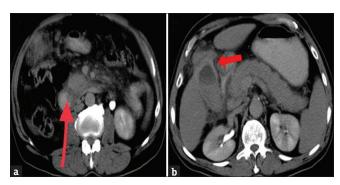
(a) Contrast-enhanced abdominal computed tomography image showing dilated common bile duct with intraluminal fi lling defects (plain arrow) and (b) computed tomography image showing perforated gallbladder and pericholecystic collection (block arrow)
